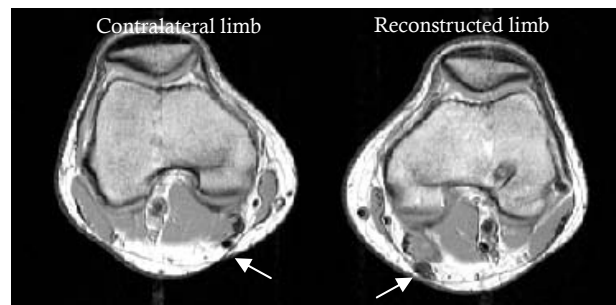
Typical MRI of the ST tendon (arrow). Tendon-like structure of the ST was confirmed at the ST tendon harvest site.
